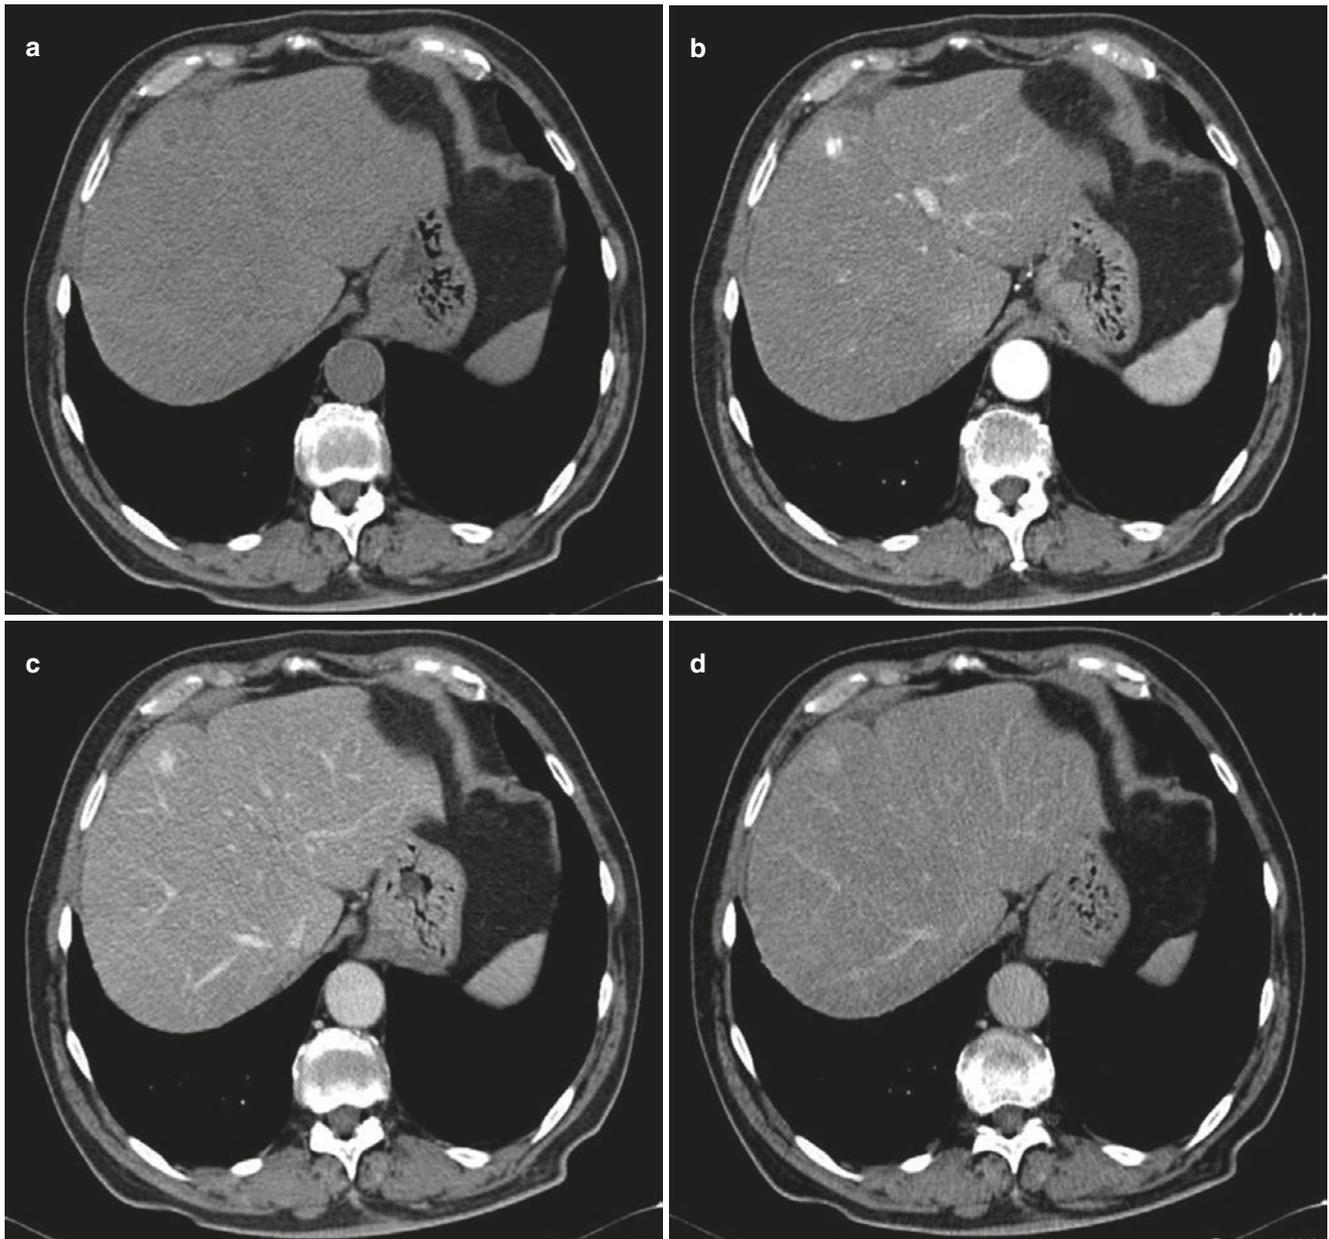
(a–d) Capillary “flash-filling” haemangioma in the right hepatic lobe. Unenhanced CT scan (a) demonstrates a centimetric sub-capsular hypodense lesion in the IV segment. On arterial phase (b) the lesion shows homogeneous vivid enhancement similar to the aortic one.
